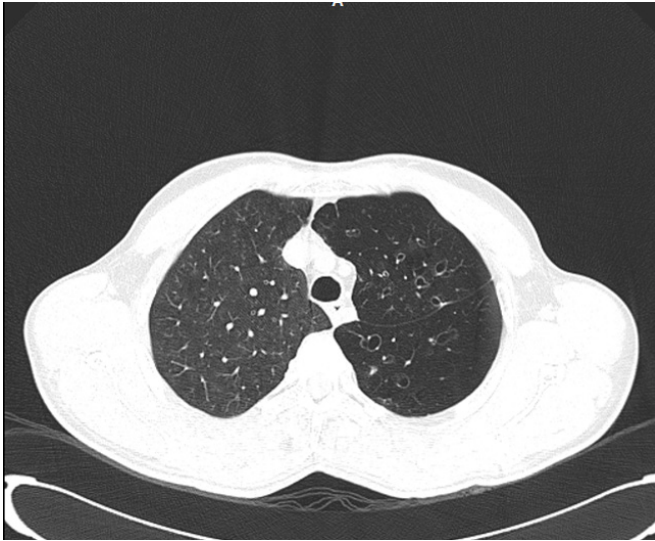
High resolution chest CT showing decreased attenuation, avascularity and bronchiectatic changes of the left lung
